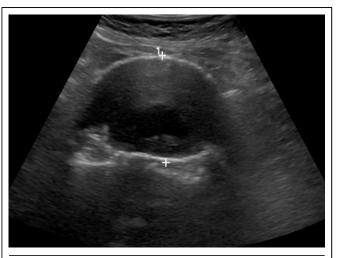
A transverse view of an AAA using ultrasound, with a thrombus present on the posterior wall. The central lumen measures I 6mm in diameter, but the aneurysm is actually 54mm
